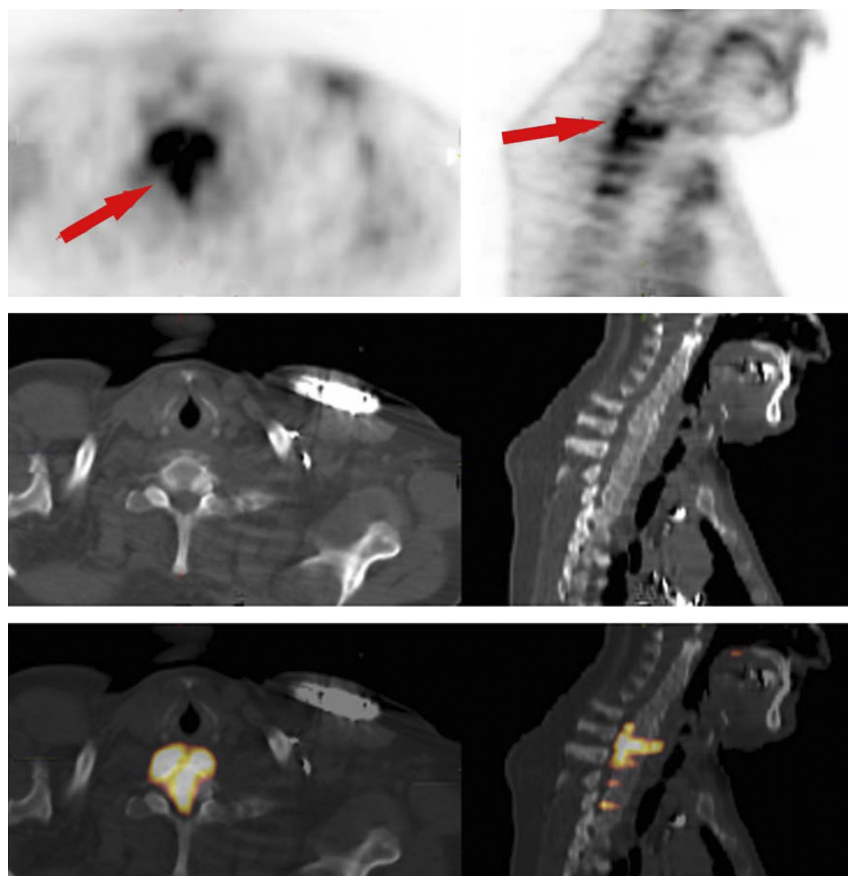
A 65-year-old man with *Staphylococcus aureus* bacteremia and persistent fever despite antibiotic therapy. Top to bottom, FDG-PET, CT, and fusion; left, transverse; right, sagittal slices. FDG-PET/CT shows abnormal FDG uptake (arrows) compatible with C6-7 spondylodiscitis and spreading inside the spinal canal compatible with an epidural abscess. The latter was confirmed on CT myelography. MRI was not possible due to the patient's intracardial defibrillator. [This figure can be viewed in color online at <http://www.md-journal.com>.]
